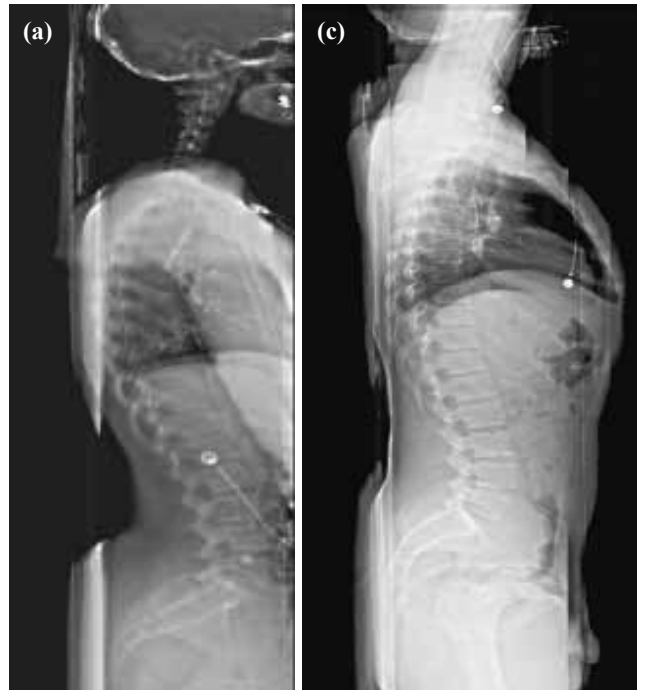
Lateral scans of (a) the whole body spine, (b) the cervical spine, and (c) the thoracic and lumbar spine. The images are of good quality and comparable to those produced by conventional radiography.
